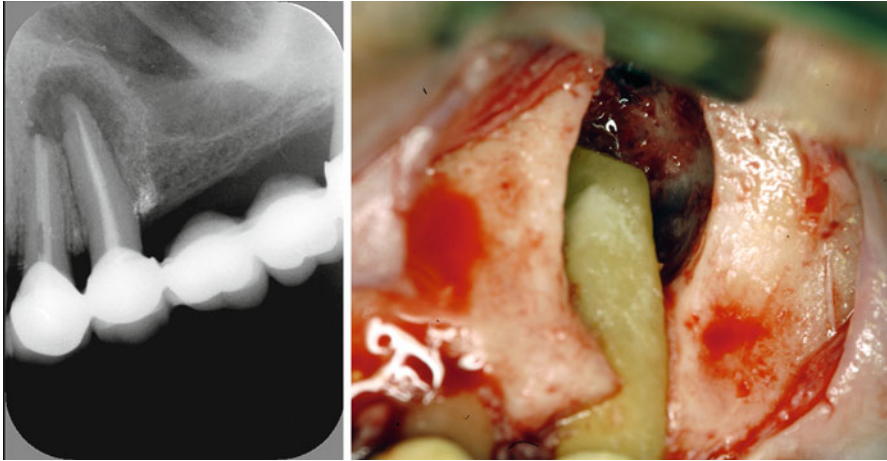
Preoperatively and from the radiograph (*left*), this defect appeared localized and perhaps readily managed. However, after raising the flap (*right*), the full extent of the apicomarginal bone defect became visible (Reprinted from Merino 2009, with permission)
